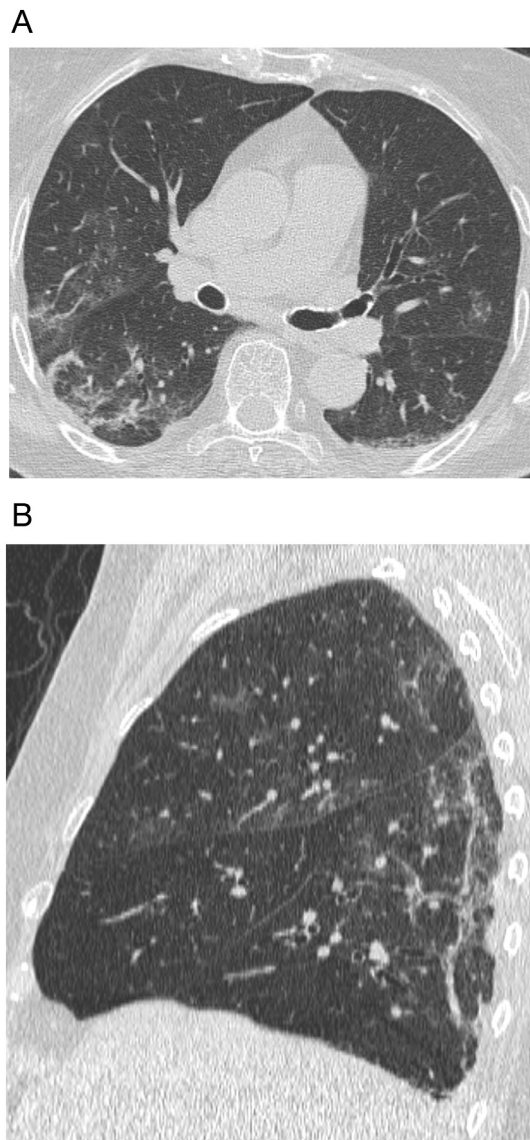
82-year-old man with confirmed severe acute respiratory syndrome coronavirus 2 disease (COVID-19) pneumonia and no comorbidities. High-resolution computed tomography (HRCT) was performed on day of hospital admission.
